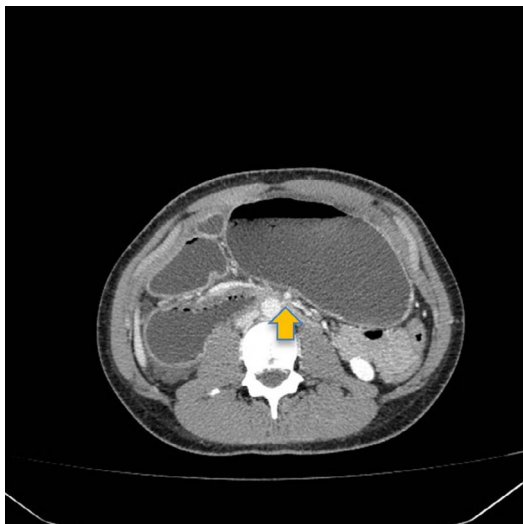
Abdominal CT scan noting obstruction of 3rd part of duodenum between aorta and SMA
